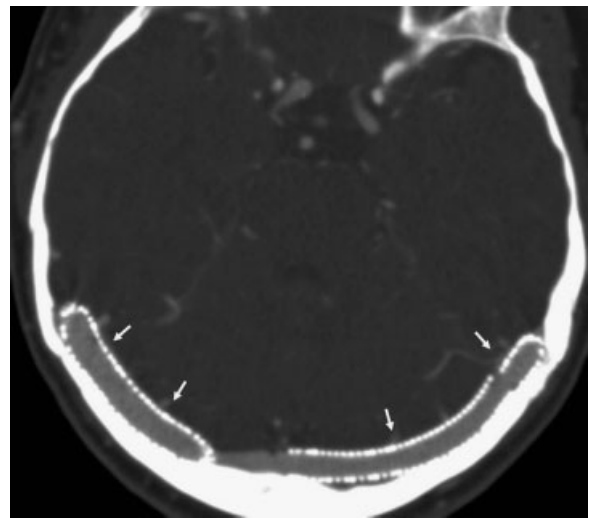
Axial computed tomographic venogram. This shows widely patent stents in both transverse sinuses (arrows).
